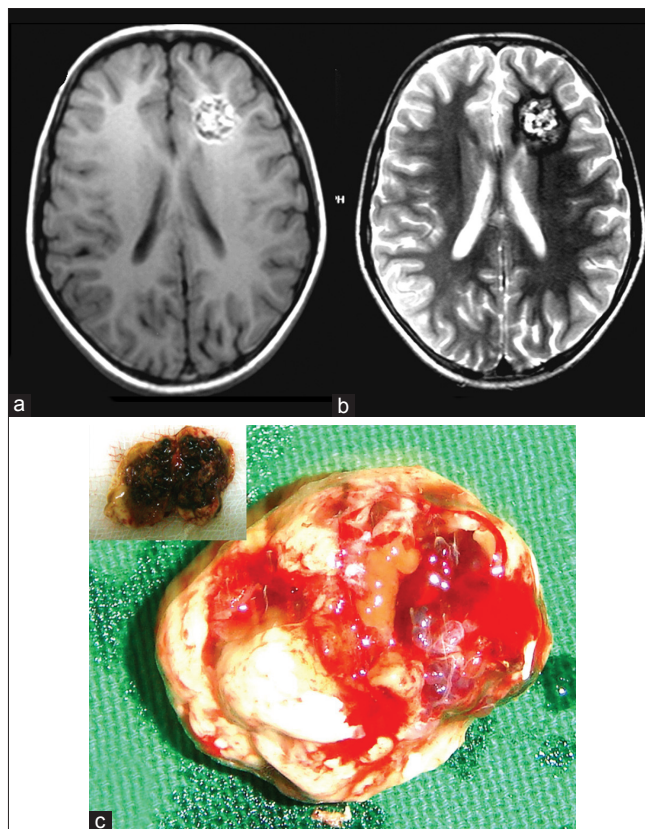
(a) and (b) MRI T1W, T2W axial images showing reticulated core of mixed signal representing blood in various states of degradation, note the hypointense halo due to hemosiderin on T2 W image (b), (c) Photograph of completely excised lesion with surrounding gliotic tissue
